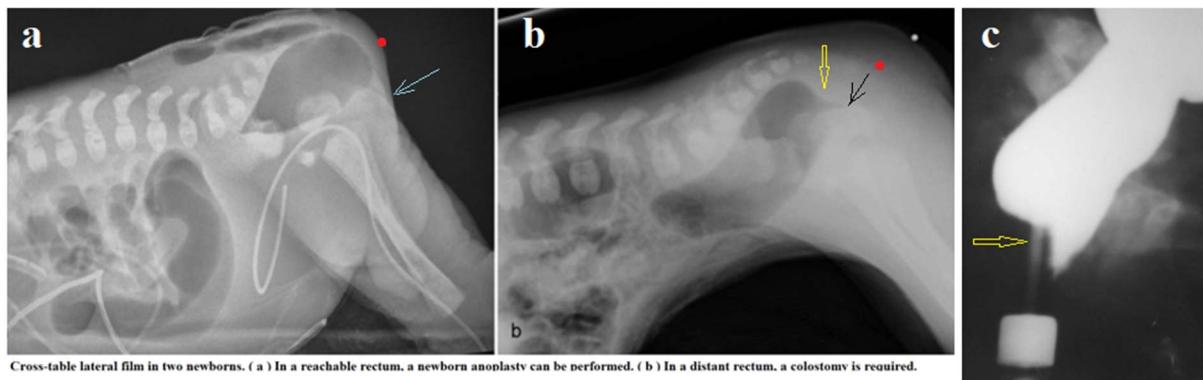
(a, b) From Wood and Levitt [6] with their caption. My designations. (a). A premature boy (small vertebrae, no buttocks) with phlegmon in the sacrococcygeal region (gas under the skin). The zone of peristaltic contraction of the rectum with the expulsion of gas into the wide anal canal is visible. The blue arrow shows a narrow perineal fistula. The red dot is located at the putative location of the anal dimple. Judging by the fact that phlegmon had time to appear, this child is at least several days old, which confirms the presence of a fistula. (b) The radiographic equivalent of the rectoanal inhibitory reflex is seen in this full-term girl. The black arrow shows the penetration of gas into the upper anal canal because of the relaxation of the internal anal sphincter. The posterior wall at this level is pressed by the contracted PRM (yellow arrow). The contrast marker should be near the anus between the buttocks (red dot), not at the top of the buttock. It is drawn on the roentgenogram. (c) Rectoanal inhibitory reflex in a healthy infant.
